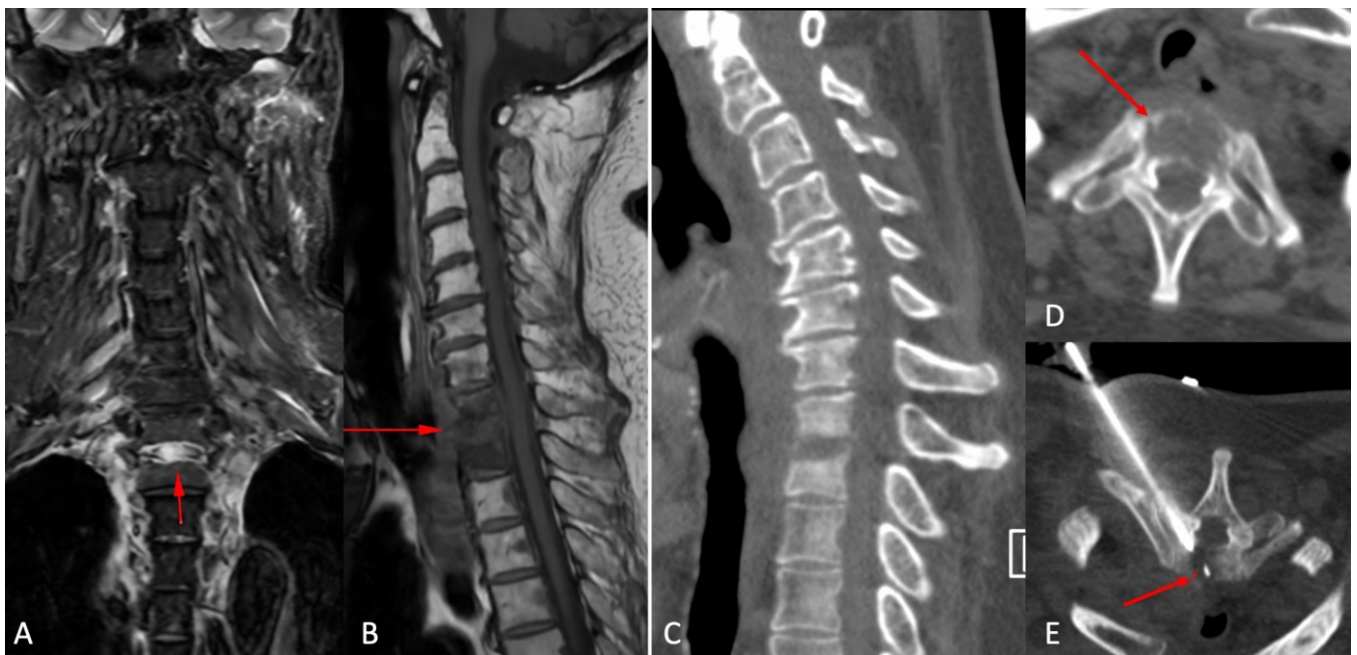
(A-E): *Rhizopus microsporus* (Mucormycosis). A 61-years old man treated for buccal cancer with radiotherapy to the neck, presented with pain and fever. STIR coronal (A) and axial T1W MRI showed typical findings (arrows) of an infective spondylitis. Sagittal (C) and axial (D) CT scans confirmed these findings (arrows). A CT guided biopsy was done using a costovertebral approach (arrow in E) and microbiology grew *Rhizopus*, which confirmed mucormycosis. He is clinically improving on antifungals.
